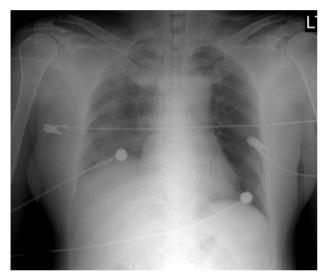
The initial chest radiograph shows an elevated Rt. Hemidiaphragm.
